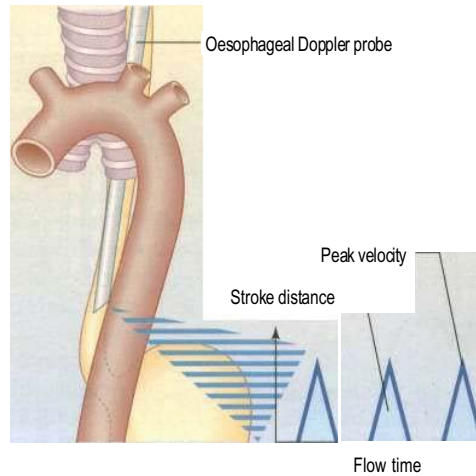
Doppler ultrasonography. An oesophageal Doppler probe continuously measures velocity waveforms from the descending thoracic aorta. With a nomogram, stroke distance (area under waveform) provides an estimate of stroke volume. Acceleration and peak velocity indicate myocardial performance, while flow time is related to circulating volume and peripheral resistance. From Singer M, Grant I (eds) (1999) *ABC of Intensive Care*. London: BMJ Books, with permission.
